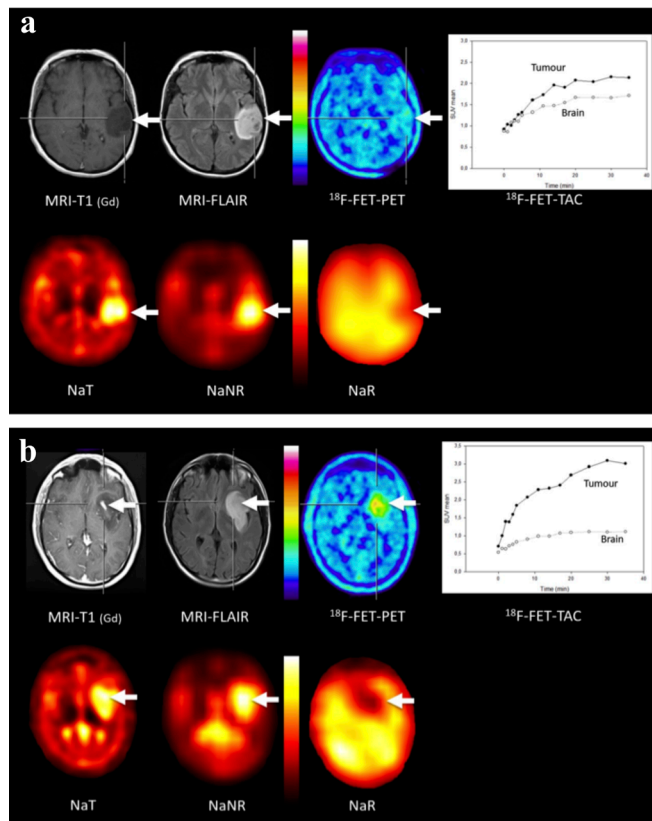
a: MRI and PET of a 35-year-old patient with an IDH mutated anaplastic astrocytoma WHO grade III (white arrow). The tumor shows no contrast enhancement in the T₁-weighted MRI and is clearly delineated in the FLAIR image. [^{18}F]FET-PET shows no significant tracer uptake in the tumor and an increasing time activity curve. Sodium imaging shows increased NaT, increased NaNR, and decreased NaR, which is the typical finding for IDH mutated gliomas. b: MRI and PET of a 38-year-old male patient with an IDH mutated glioblastoma WHO grade IV. The tumor (white arrow) shows focal contrast enhancement in the T₁-weighted MRI and is clearly depicted in the FLAIR image. [^{18}F]FET-PET shows significant tracer uptake in the tumor and an increasing time activity curve. Similar to the IDH mutated glioma in Figure 1a sodium imaging shows increased NaT, increased NaNR, and decreased NaR.
